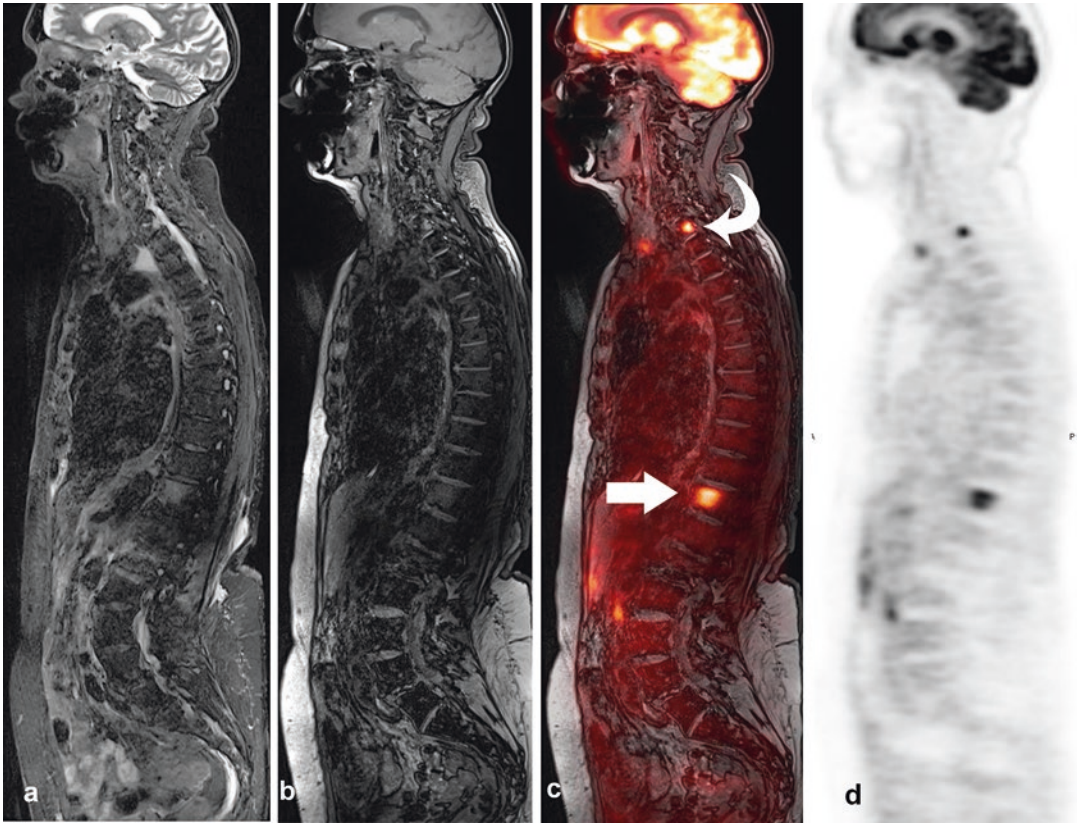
STIR sagittal (a), Dixon T1-weighted out-of-phase sagittal (b), PET/MR Dixon T1-weighted out-of-phase sagittal fusion (c), and PET sagittal (d)
